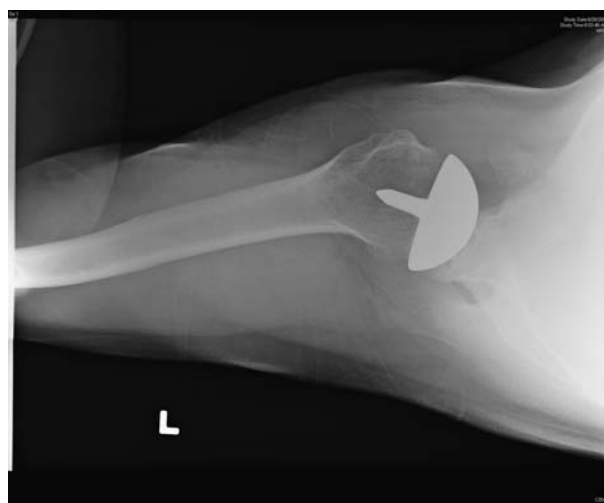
The magnetic resonance imaging scan will reveal the degree of cyst formation within the glenoid, detailing whether evacuation or resurfacing (or both) of the glenoid will be necessary.
